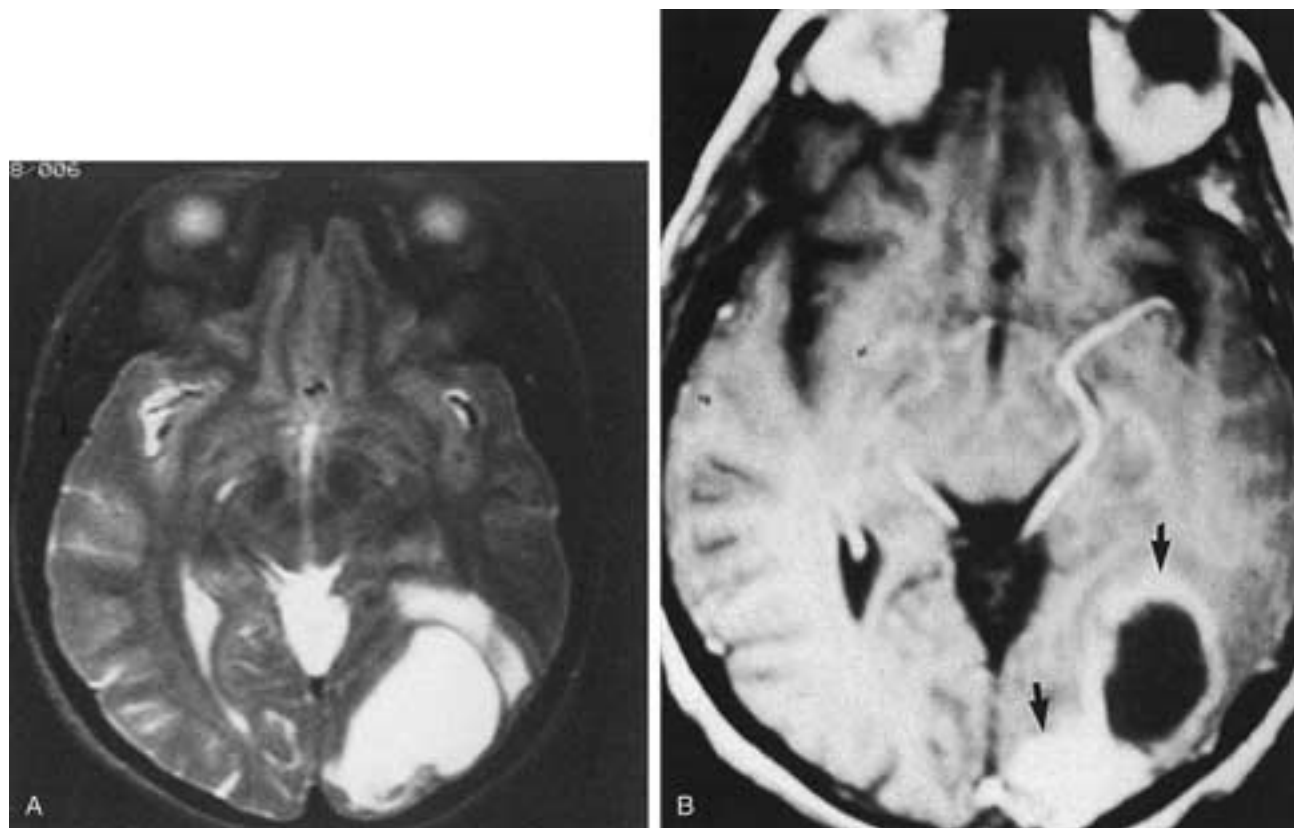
Occipital lobe metastasis from carcinoma of the lung. A, Axial T2-weighted image shows hyperintense mass in the left temporal occipital region; a point of separation exists between the most posterior portion of the mass and the anterior segment of high signal intensity edema in adjacent white matter. B, Axial T1-weighted image after injection of contrast medium shows tumor enhancement (*arrows*).
